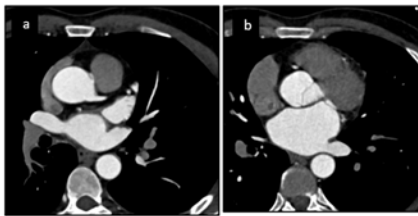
38 Y/M, c/o intermittent chest pain, CT coronary angiogram axial images showing malignant origin of right coronary artery from left coronary sinus and coursing between aorta and pulmonary trunk.
